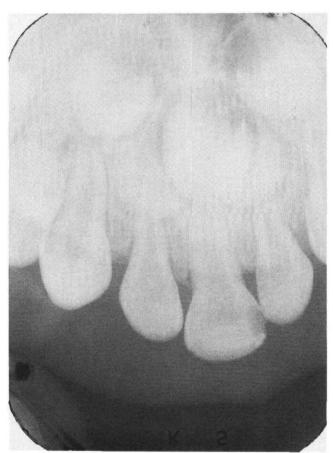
Apical radiograph taken at age 3 years, 6 months. A single maxillary primary central incisor is clearly evident. Note the single maxillary permanent central incisor on the midline of the maxilla.
